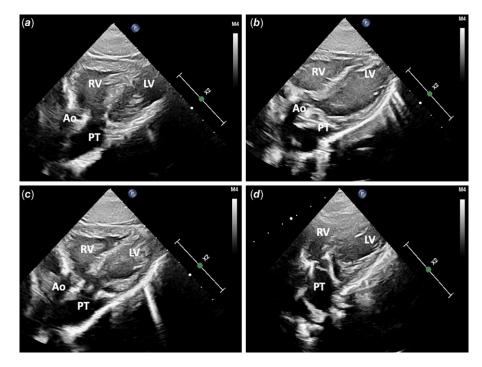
Transthoracic two-dimensional echocardiographic images. (*a*) The angle that suggest double outlet right ventricle in subcostal view. (*b*) The angle that suggest double outlet left ventricle in subcostal view. (*b*) The angle that suggest discordant ventriculoarterial connection in subcostal view. (*d*) The angle that suggest concordant ventriculoarterial connection (right ventricle-pulmonary artery) in subcostal view. Ao=aorta; PA=pulmonary artery; RV=right ventricle; LV=left ventricle.
